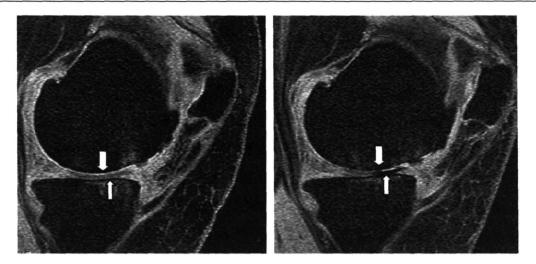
MR image showing a cartilage defect score at both medial tibia and medial femur progressed from grade 3 at baseline to grade 4 at follow-up.
